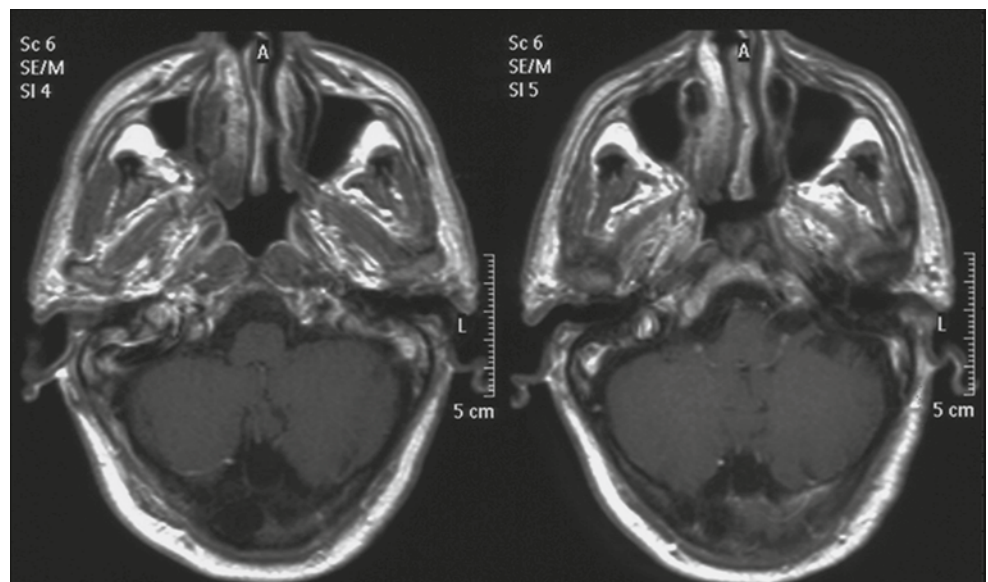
Axial T1-weighted MR images with gadolinium show only a subtle enhancement of the lesion margins
